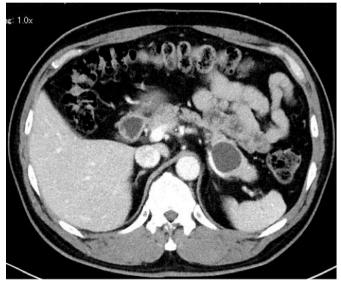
The abdominal CT scan revealed a 30-mm unilocular cystic lesion in the pancreatic body.
